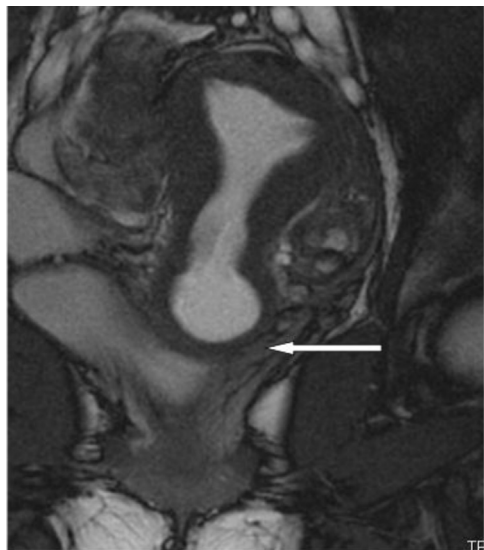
In patient 1, initial magnetic resonance imaging scan showed blood products distending and endometrial cavity and cervical canal. The collection was thought to be the result of a transverse septum in the upper vagina (arrow). The lower vaginal canal was clinically thought to be atretic.
